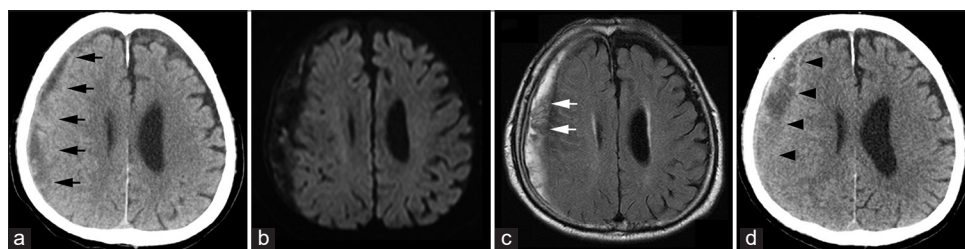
(a) Head computed tomography (CT) shows right chronic subdural hematoma (CSDH) (black arrows). (b and c) Magnetic resonance imaging demonstrates uniform hyperintensity on diffusion-weighted imaging and hyperintensity with intrahematoma membrane structures on fluid-attenuated inversion recovery (white arrows). (d) One-month follow-up CT after the abatement of fever indicates a slight increase (black arrowheads) in the CSDH size.
